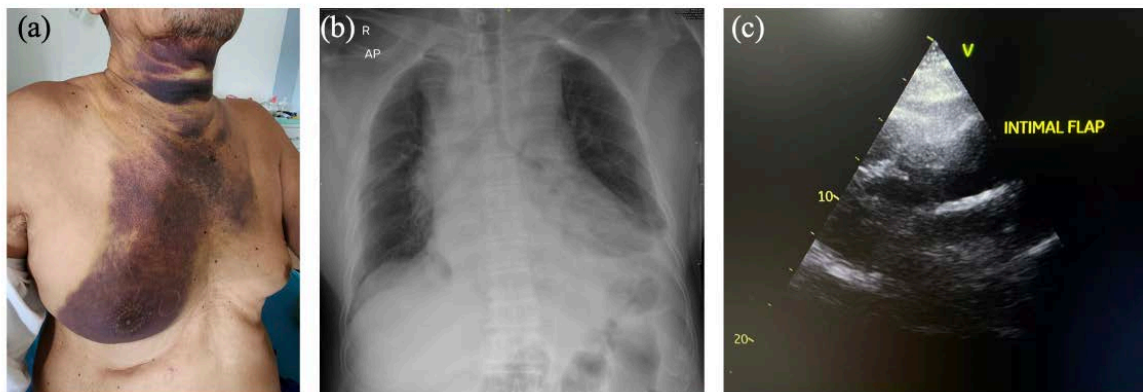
(a) Physical findings of anterior chest ecchymosis extending to the neck area. (b) Chest x-ray showed mediastinal widening and double aortic contour, as it is suggestive of aortic dissection. (c) Transthoracic echocardiography showed an intimal flap in the aortic root.
